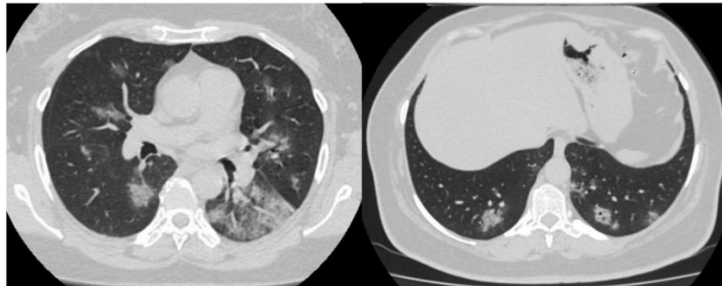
Examples of image slices sampled from a 3D CT scan.[2]
